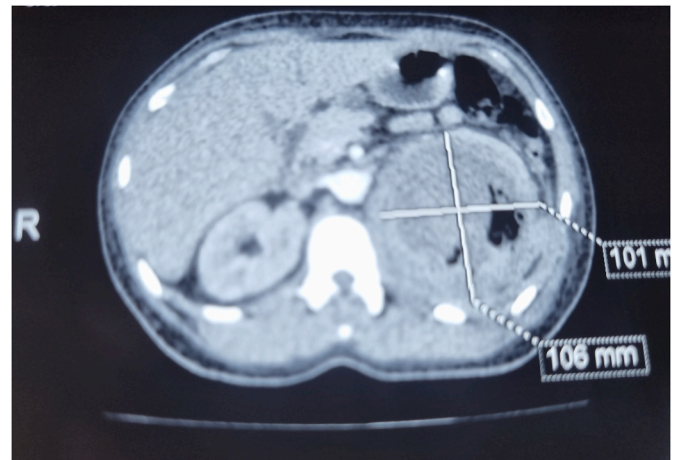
Axial section of the abdominal CT scan showing a perirenal hematoma measuring 101 × 106 × 107 mm.
